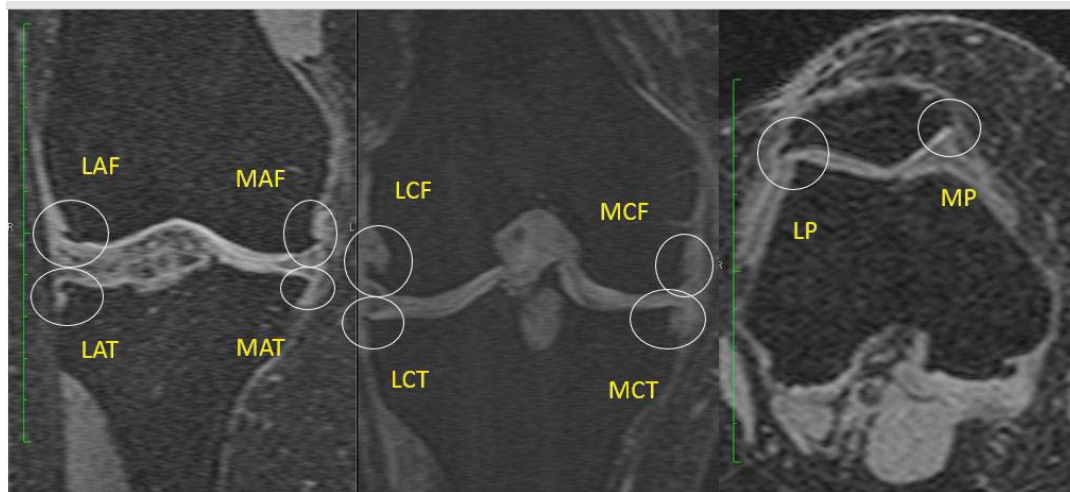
1 Examples of osteophytes assessed at different sites on MRI
